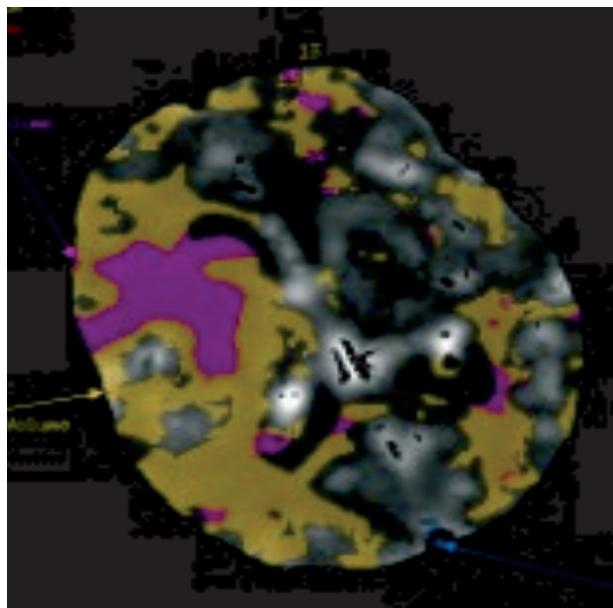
CT perfusion. CVI of right temporal lobe
